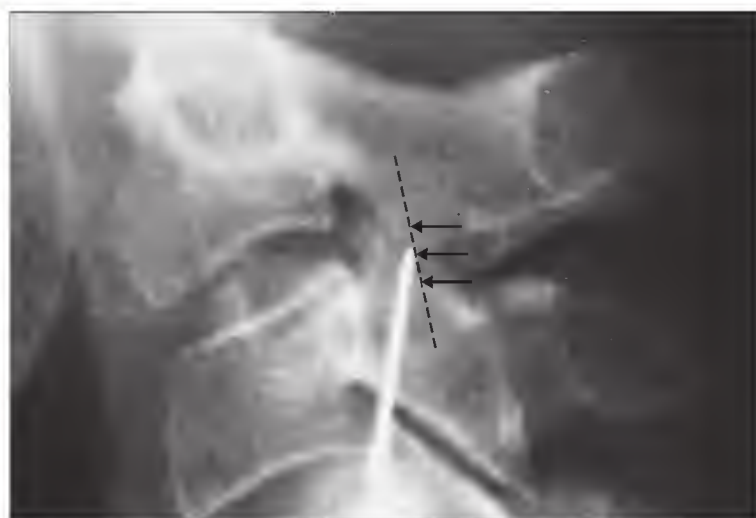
Injecting the third occipital nerve. On a lateral radiograph of the cervical spine, arrows indicate the target points for injections to anesthetize the third occipital nerve and thus the C2-3 zygapophyseal joint. The points lie along a line that vertically bisects the articular pillar of C3 seen on a lateral projection. The middle point lies over the joint line, the upper point over the subchondral plate of the C2 inferior articular surface, and the lower point over the subchondral plate of the superior articular surface of C3.
